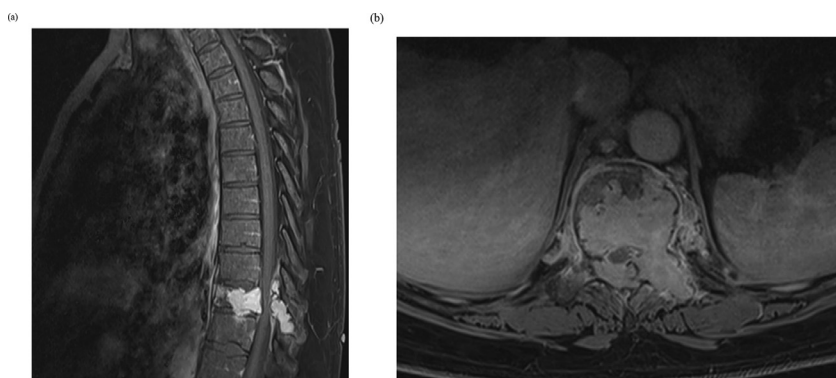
Sagittal (a) and Axial (b) T1 Post Gadolinium MRI: Expansile lytic lesion involving the T10 vertebral body and posterior elements with pathologic fracture and epidural compression.
